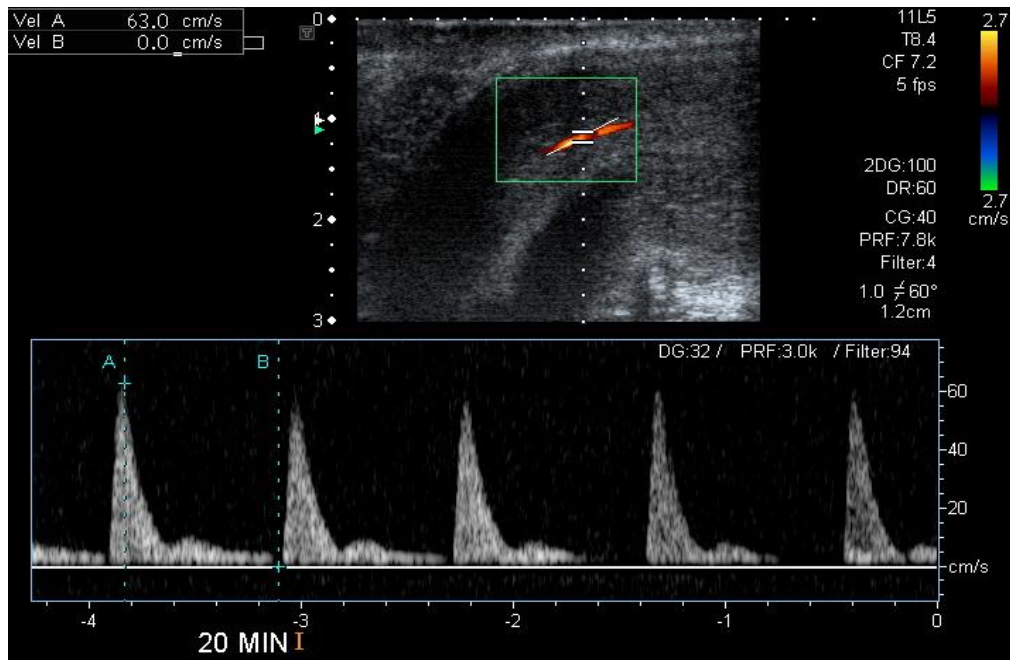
Color doppler at 20 minutes showing good flow
